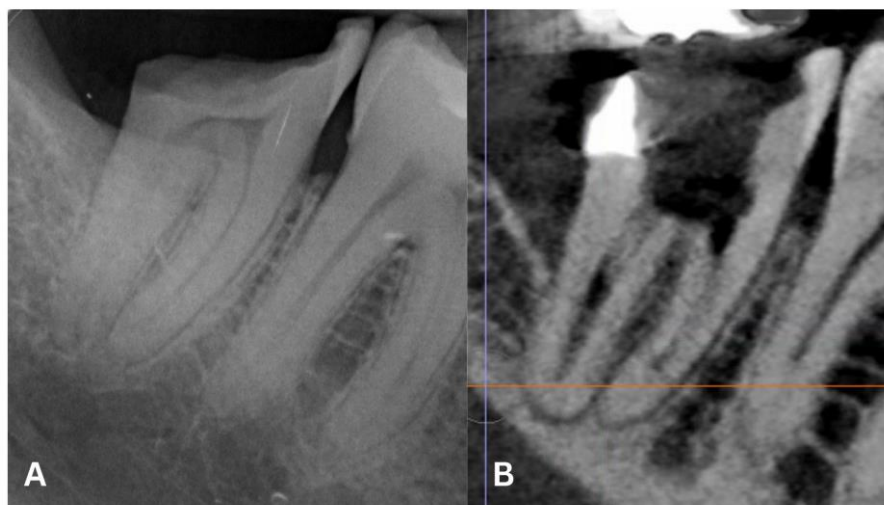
Case 3. Pre-operative radiographs. (A) X-ray taken by the referring dentist and sent with the referral and occurred prior to the perforation. (B) Pre-operative CBCT showing a perforation of the floor of the pulp chamber
